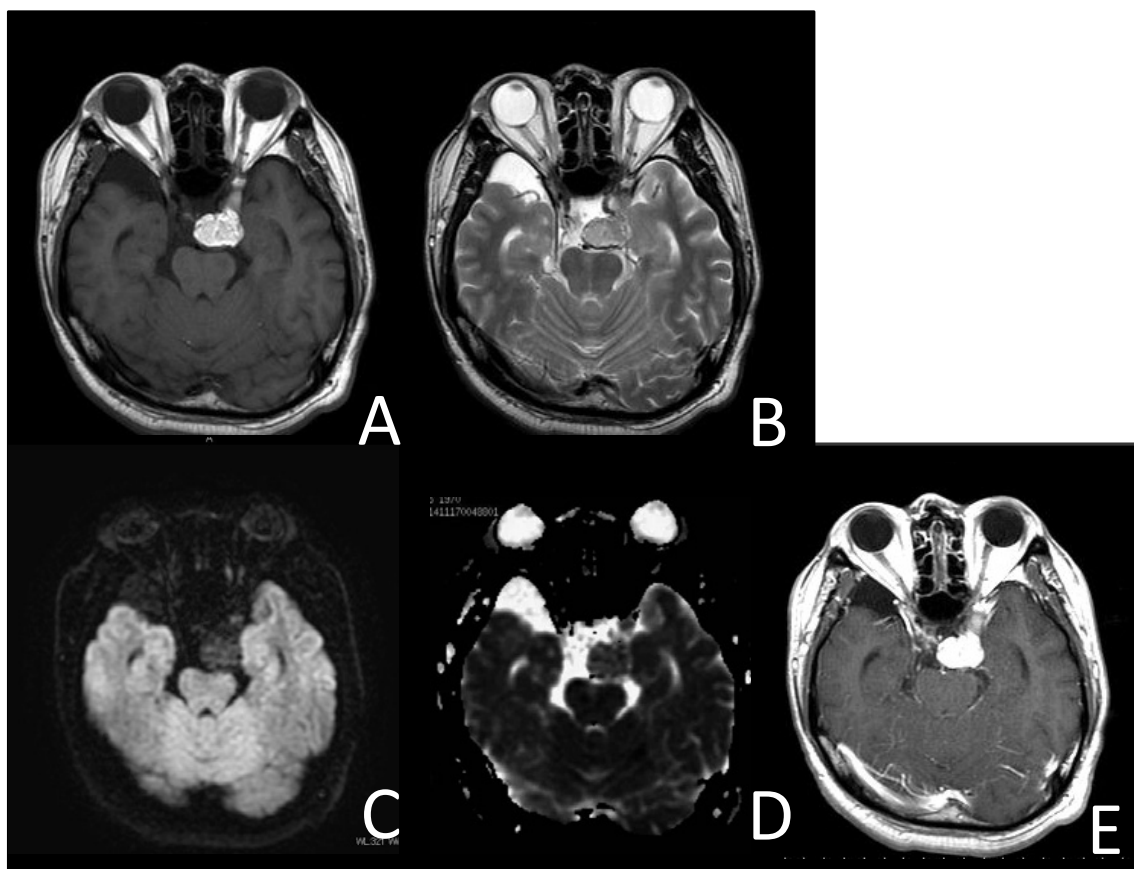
Brain MRI at the initial visit.
